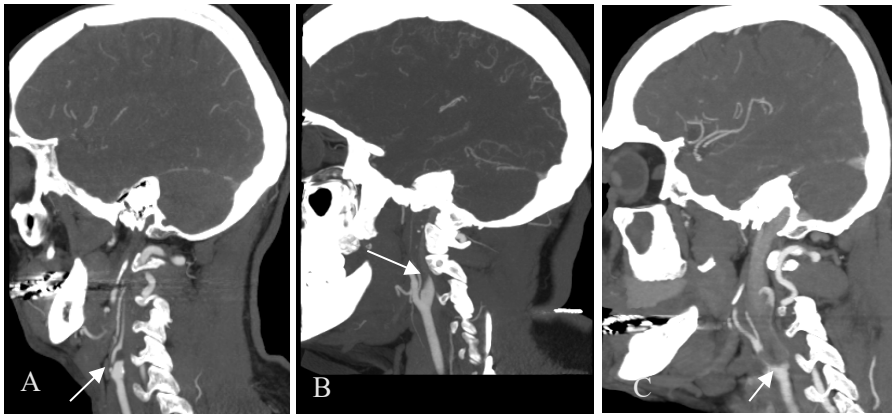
CTA – sagittal projections. A: Stenosis in proximal ICA (arrow). B: Dissection in ICA (arrow). C: Large embolus lodged in the carotid bifurcation (arrow).
